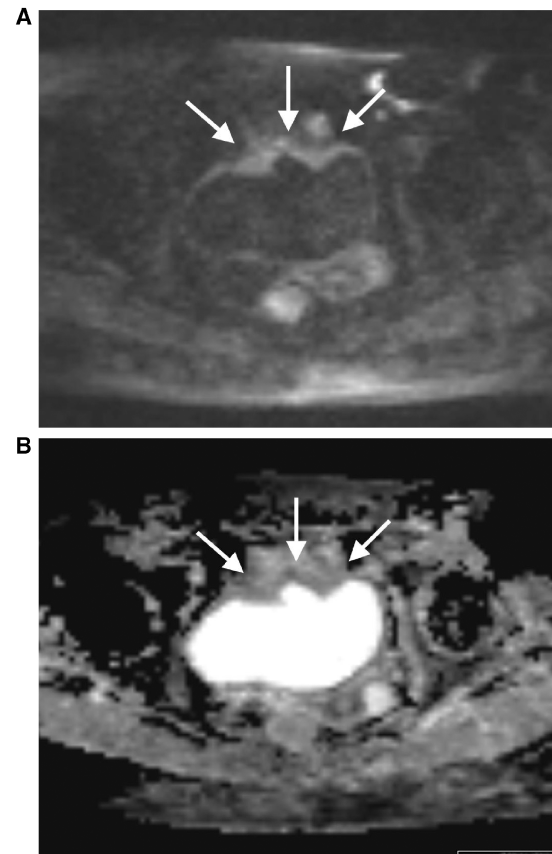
MRI (at 3 T) of a 69-year-old female patient with a pT3 TCC of the bladder. (A) On the DW-MR image at a b value of 1000 s/mm^2 the tumour is seen as thickening of the anterior bladder wall with high signal intensity and with irregular outer margins extending into the surrounding fat tissue (arrows). (B) On the corresponding ADC map the tumour is visualized as thickening of the bladder wall with impeded diffusion, represented by colour shades of dark grey (arrows).
